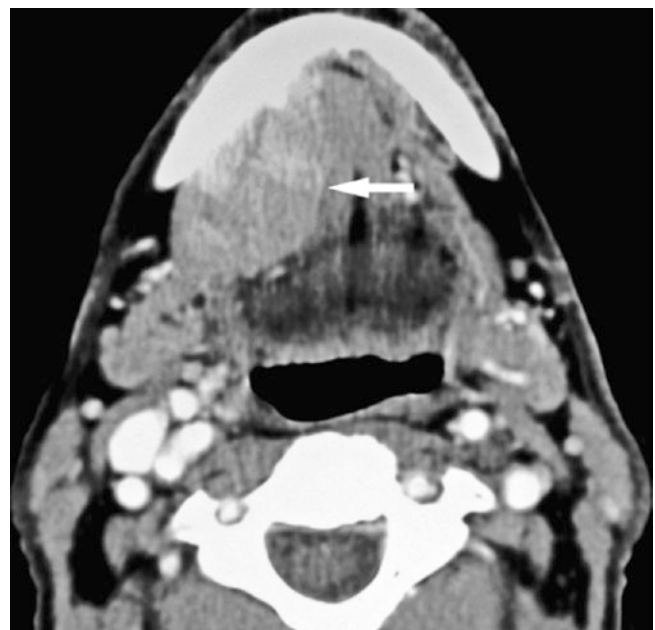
Sublingual gland adenocarcinoma; 84-year-old male with Marfan syndrome and aortic insufficiency, presenting with moderately tender sublingual lump. Axial post-contrast CT image shows rather well-defined contrast-enhancing sublingual mass (*arrow*) extending to submandibular gland region, dislocating the right genioglossus muscle toward the left and mylohyoid muscle laterally and inferiorly
